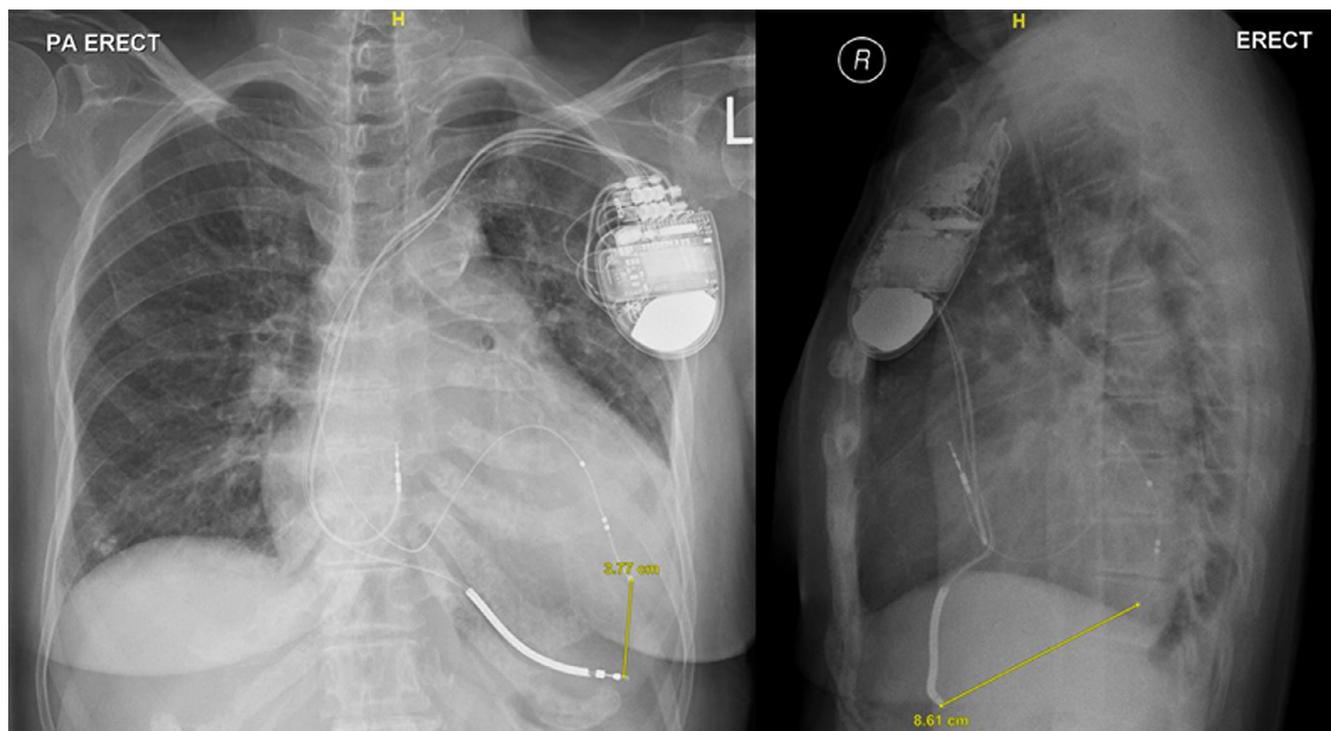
Interventricular lead separation distances obtained from posteroanterior and lateral chest X-rays.
